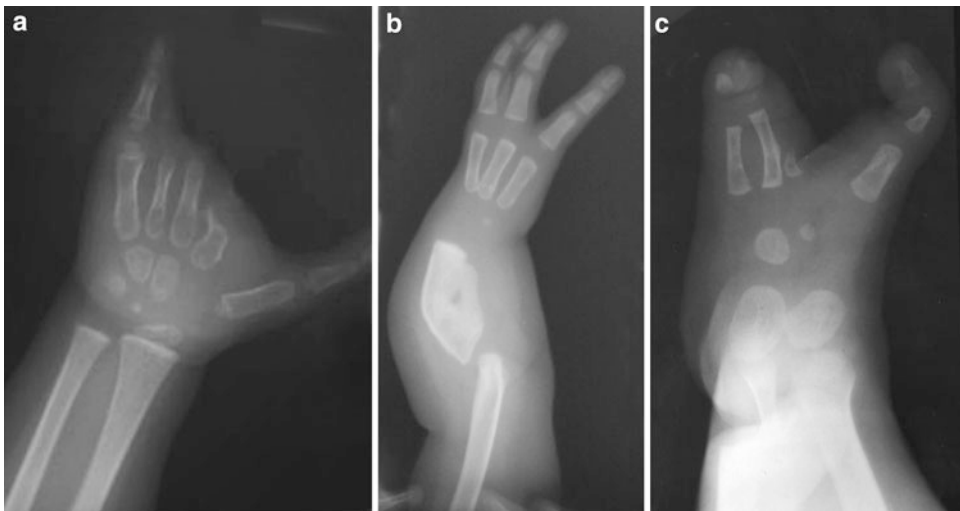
Radiographs of ectrodactyly (two hands (a, b) and a foot (c)) in three patients showing different types of ectrodactyly
